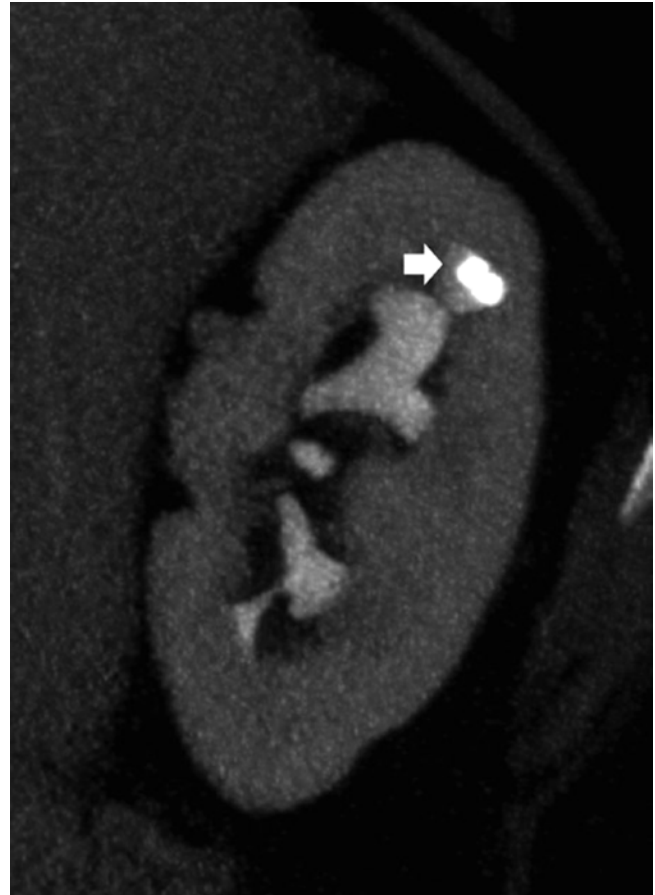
CT urography. Coronal reformation. Renal calculus within a calyceal diverticulum (*arrow*) on the upper calyces of the left kidney (Courtesy of Prof. E. Quaia)
